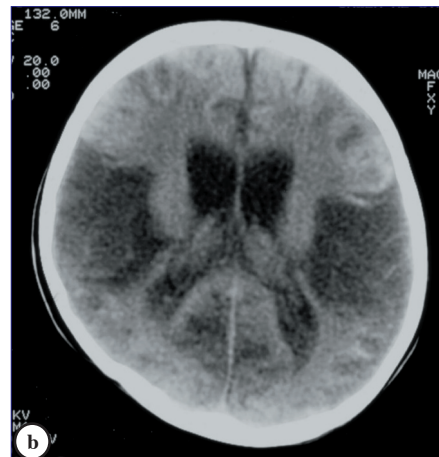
a & b) Axial brain CT images showing bilateral symmetrical low attenuation areas in the temporal, parietal and thalamic regions due to necrotizing encephalopathy.
